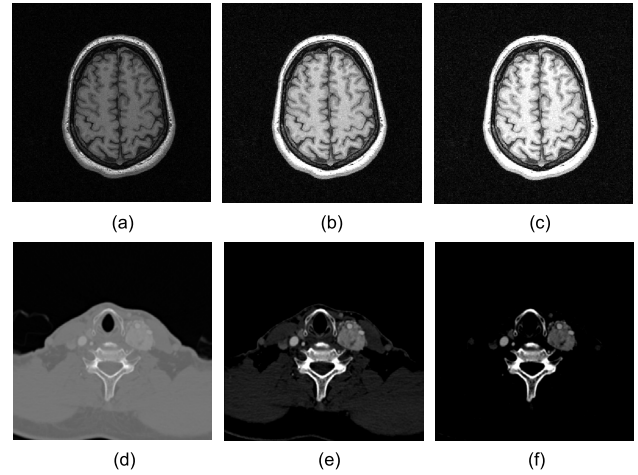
The effects of intensity transformations. In particular, (a)-(c) show how the intensity transformations can enhance the contrast among different medical materials for the Bruce dataset, and (d)-(f) show how they allow users to filter out uninterested materials and only reserve the interested materials for the CT Neck dataset.
